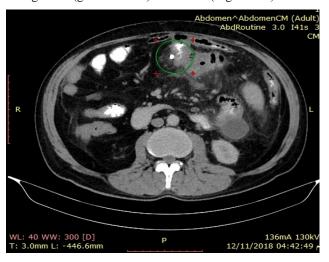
Axial computed topography (CT) scan of the abdomen showing radio-opaque tip of the biliary stenting (green circle) outside the jejunum with mesenteric fat stranding.
